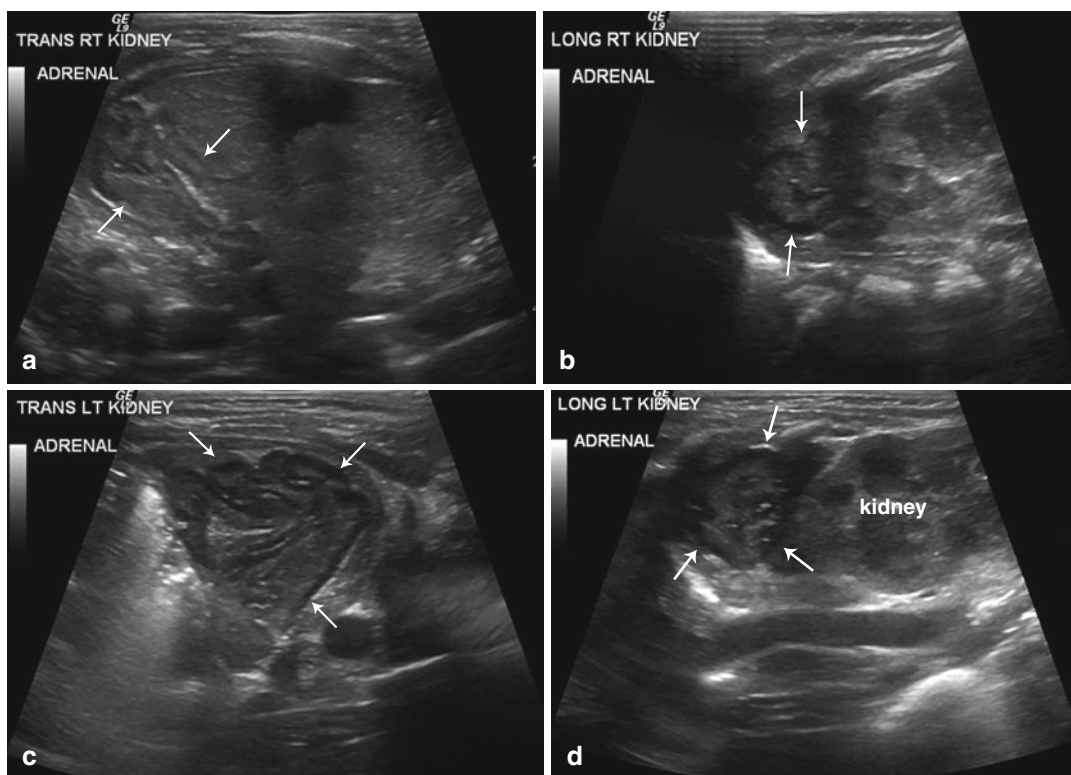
Congenital adrenal hyperplasia. Retroperitoneal ultrasound images from both flanks (a–d) performed on a newborn girl with ambiguous genitalia due to congenital
